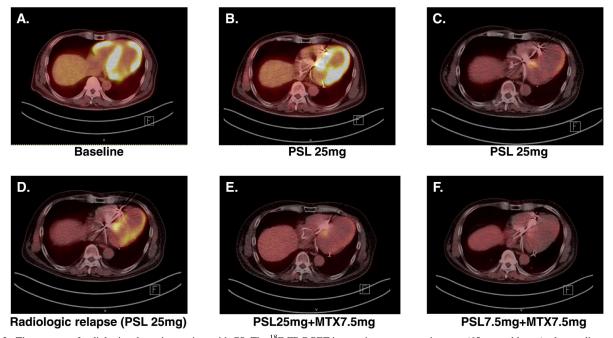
Time course of radiologic relapse in a patient with CS. The ¹⁸F-FDG PET images in a representative case (65-year-old man) taken at diagnosis (*A*), and at different periods in the course of follow-up. Three months after initiation of PSL (initial dose 30 mg for 4 weeks, then tapered to 25 mg as maintenance), high uptake of ¹⁸F-FDG was observed (*B*). Eight months after starting therapy, uptake was decreased (*C*). After 13 months, radiologic relapse was observed despite continuation of the maintenance dose (PSL 25 mg) (*D*). MTX 7.5 mg was added to the regimen (*E*). Two years after the initiation of the combination therapy, decreased uptake of ¹⁸F-FDG was again seen (F: PSL 25 mg plus MTX 7.5 mg). MTX = methotrexate.
